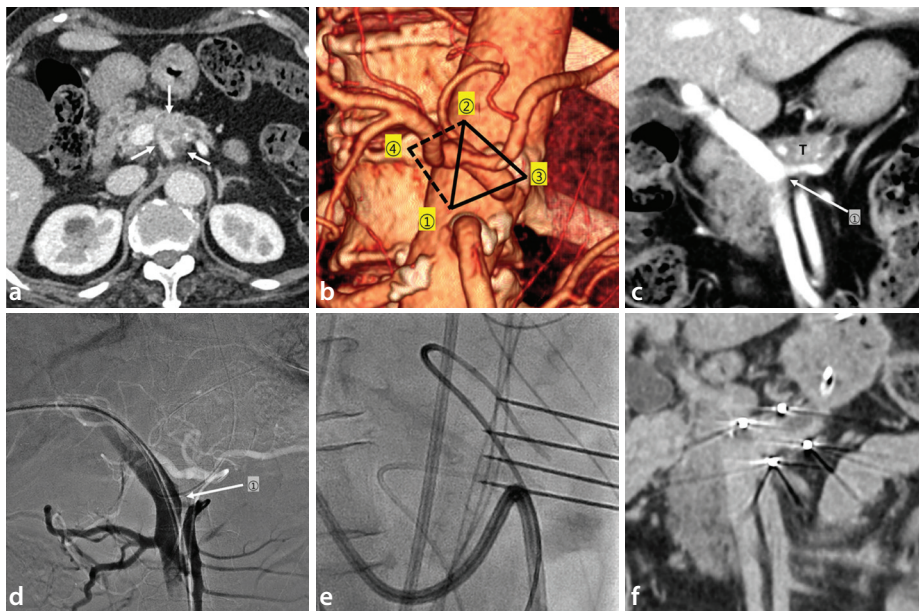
A 72-year-old woman with locally advanced pancreatic cancer. (a) Contrast-enhanced computed tomography (CT) shows a 1.8-cm mass in the pancreatic body (arrows), with encasement of the celiac trunk, common hepatic artery, and splenic artery and abutment of the main portal vein (PV). (b) Based on the tumor extent and its relationship to adjacent vascular structures, a combined configuration consisting of a triple clustered electrode with a 20-mm interelectrode spacing (1–3) and a single electrode (4) was planned. (c) The first electrode (1) of the triple clustered electrode configuration was targeted at the interval between the superior mesenteric artery and the main PV (arrow); the tumor (T) abutted the splenic vein and main PV. (d, e) Under combined arteriography and direct portography, all electrodes, including the first electrode (1), were placed with parallel alignment. (f) Verification by CT confirmed appropriate interelectrode spacing and adequate tumor bracketing. A follow-up CT obtained 7 months after IRE demonstrated stable disease (not shown), with a decrease in CA19-9 levels from 78 to 9.6 U/mL. IRE, irreversible electroporation; CA19-9, carbohydrate antigen 19-9.
